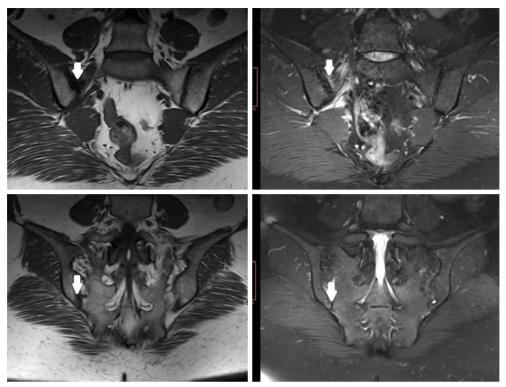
Sacroiliac magnetic resonance imaging showing active sacroiliitis.
